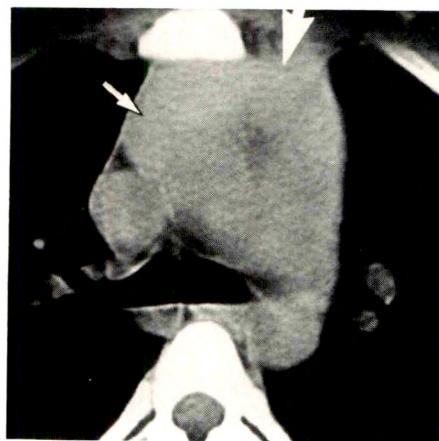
24-year-old woman with Graves disease and fullness of anterior mediastinum on chest radiograph. CT scan shows symmetrically enlarged thymus with thickened right and left lobes (arrows) related to Graves disease.
